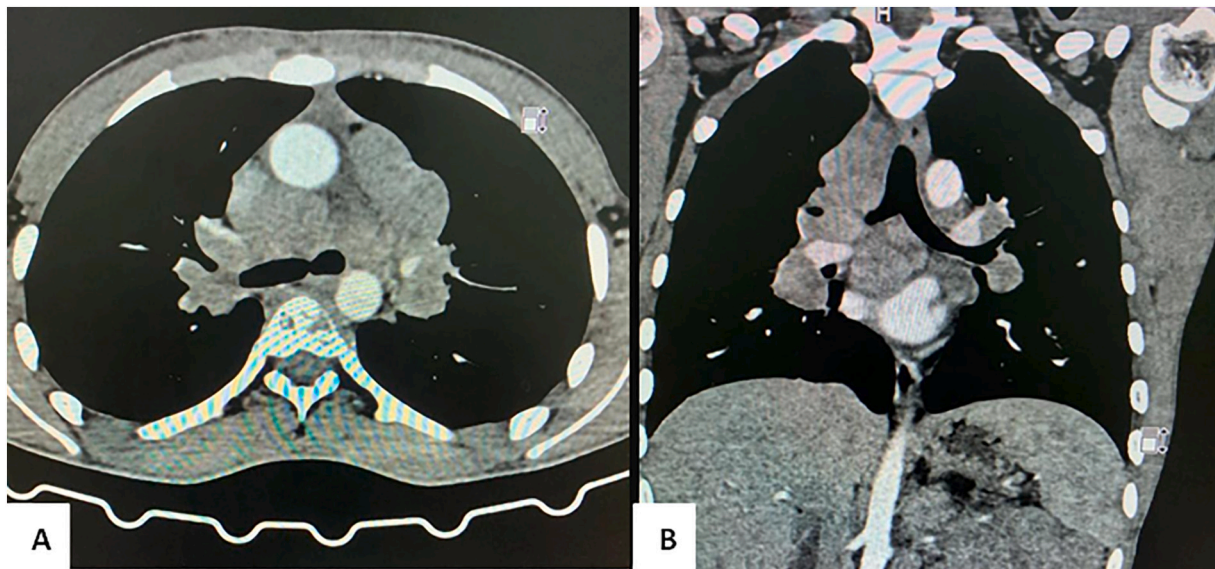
Axial contrast enhanced CT of chest displaying conglomerate mediastinal and hilar nodes with lytic lesion in vertebral body (A). Coronal reformatted image showing multiple conglomerate mediastinal and hilar nodes (B).
